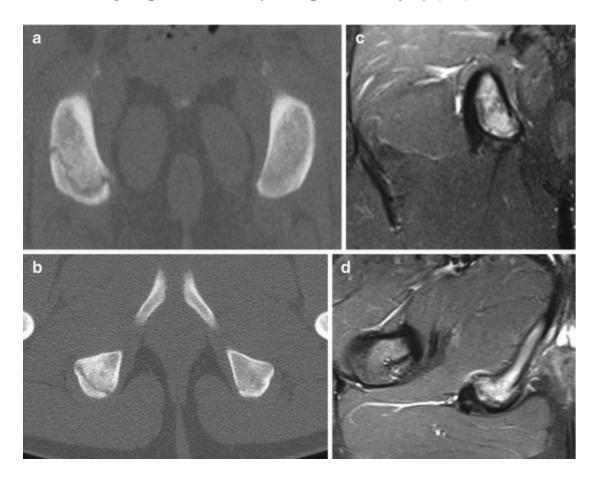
A 17-year-old professional male gymnast with apophsitis. Coronal (a) and axial (b) CT images show widening and irregularity of the physis. Coronal (c) and axial (d) fat-suppressed proton density-weighted MRI also show physeal widening associated with bone marrow edema
